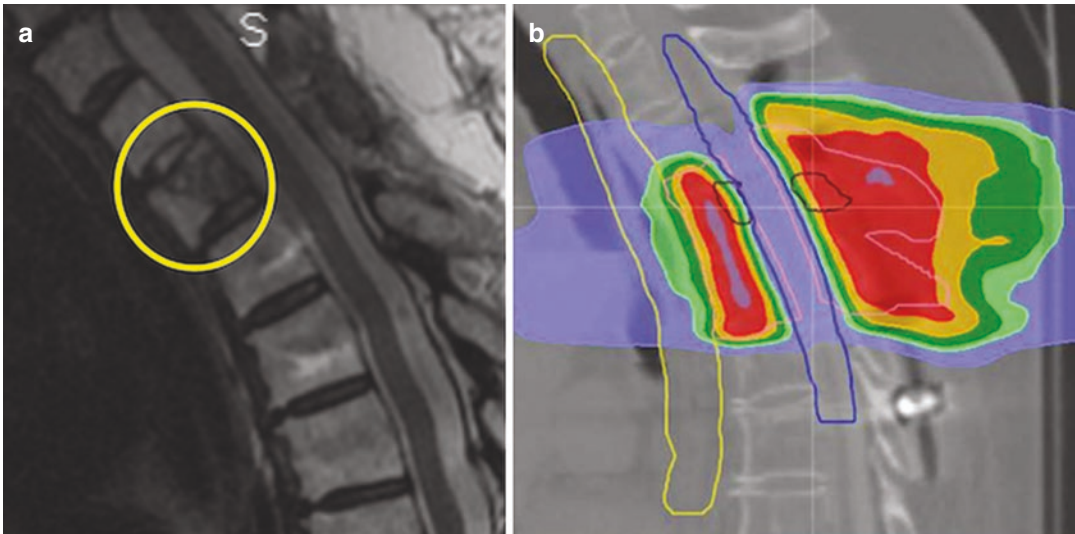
(a) Postoperative MRI Sagittal T2 image showing residual T2 vertebral body after surgery and clear resection of epidural tumor. The cerebrospinal fluid has been reconstituted after surgery, further achieving the goal of separating the tumor away from the dura and the spinal cord. (b) Screenshot from the radiation treatment plan
